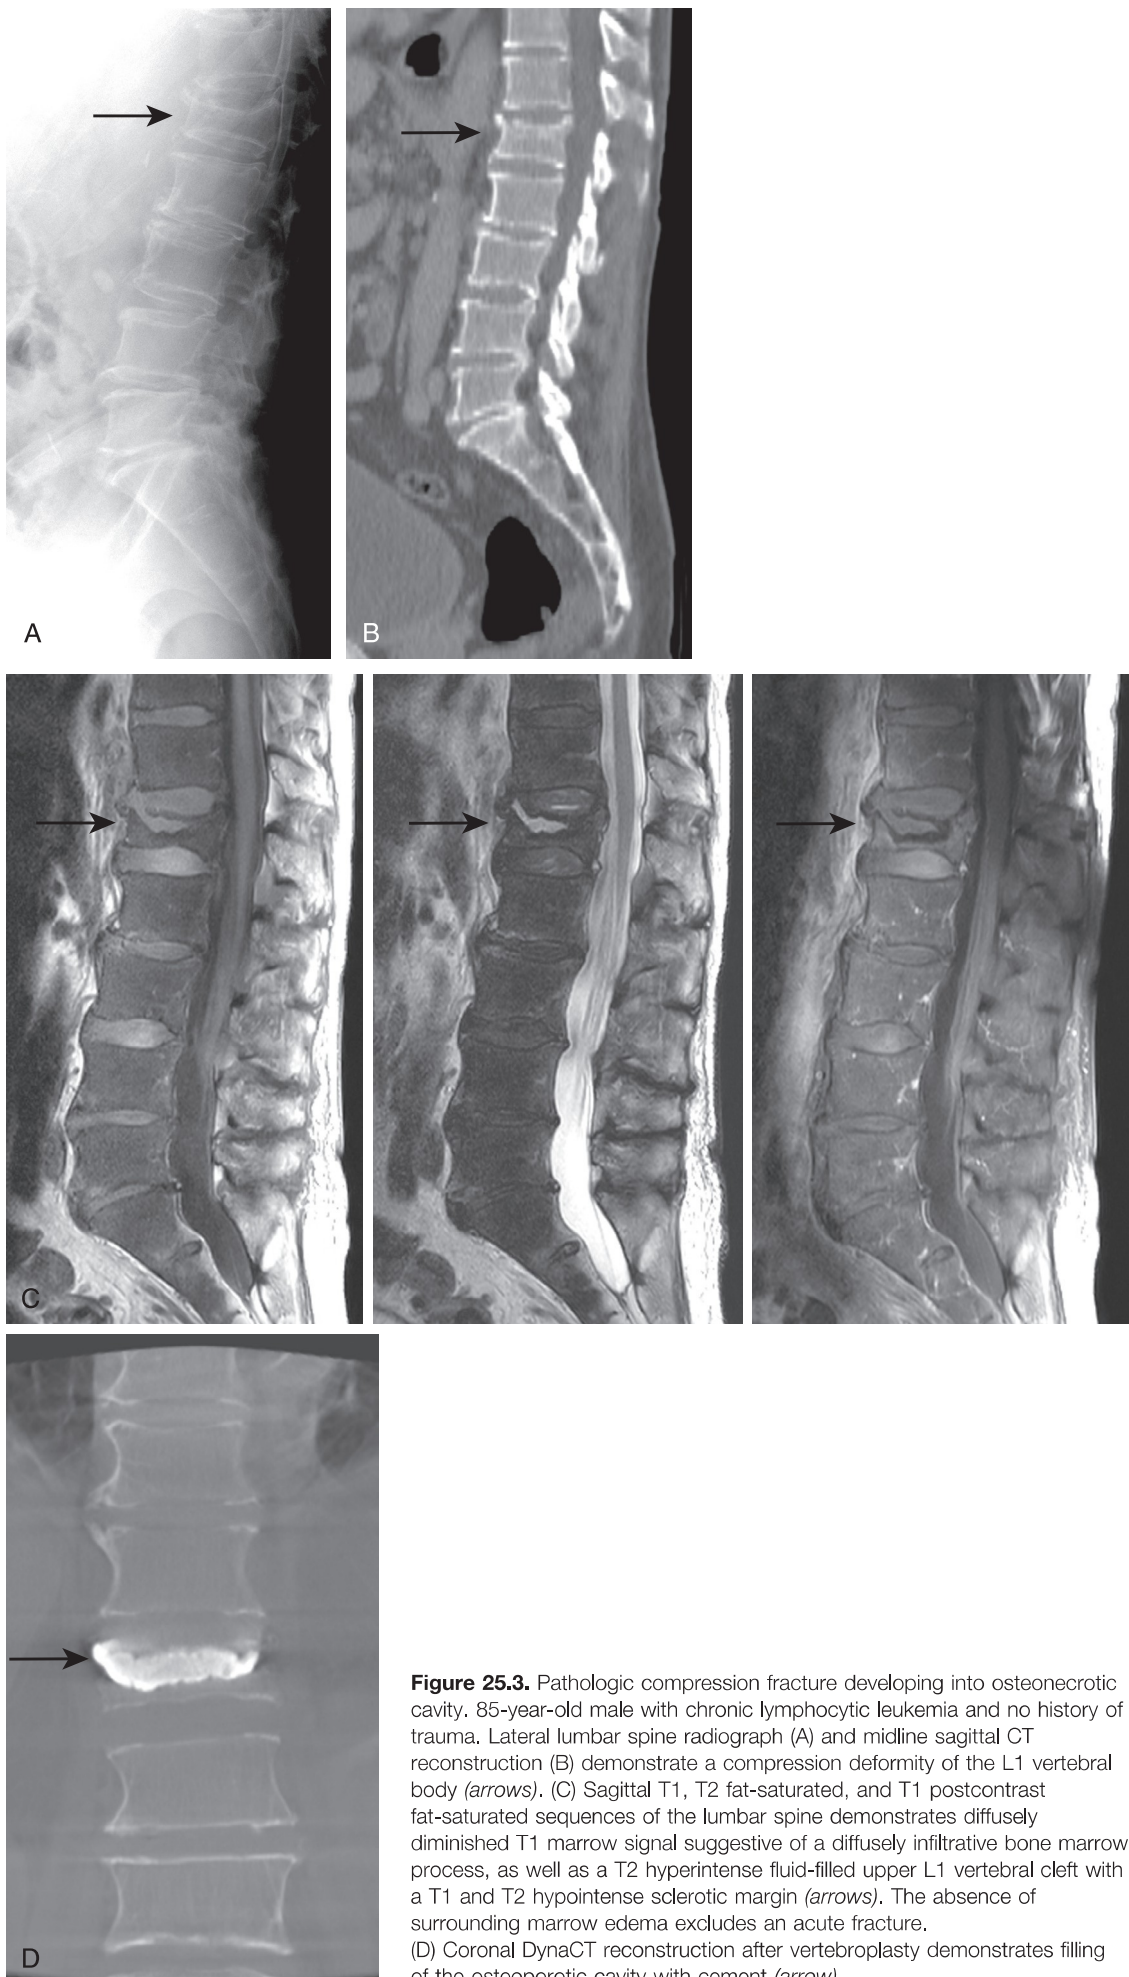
Pathologic compression fracture developing into osteonecrotic cavity. 85-year-old male with chronic lymphocytic leukemia and no history of trauma. Lateral lumbar spine radiograph (A) and midline sagittal CT reconstruction (B) demonstrate a compression deformity of the L1 vertebral body (*arrows*). (C) Sagittal T1, T2 fat-saturated, and T1 postcontrast fat-saturated sequences of the lumbar spine demonstrates diffusely diminished T1 marrow signal suggestive of a diffusely infiltrative bone marrow process, as well as a T2 hyperintense fluid-filled upper L1 vertebral cleft with a T1 and T2 hypointense sclerotic margin (*arrows*). The absence of surrounding marrow edema excludes an acute fracture. (D) Coronal DynaCT reconstruction after vertebroplasty demonstrates filling of the osteoporotic cavity with cement (*arrow*).
